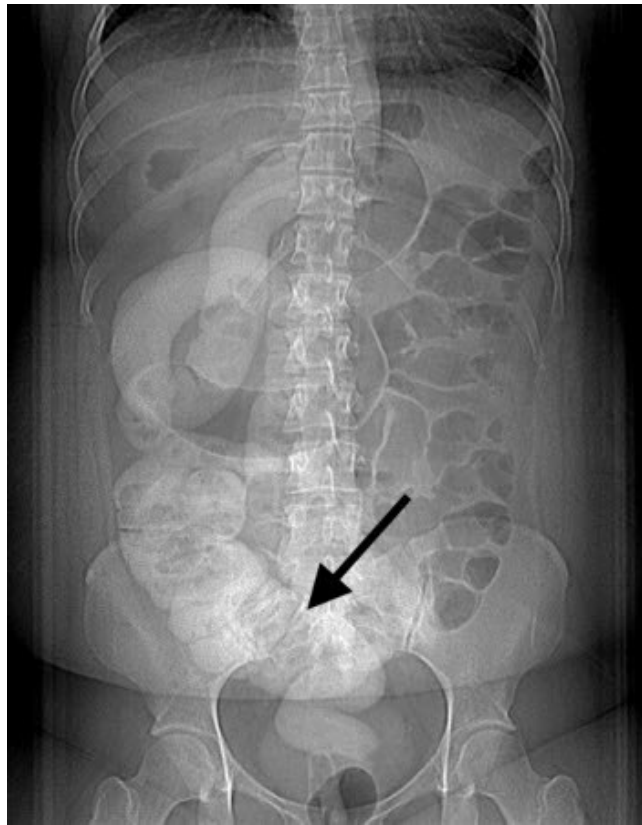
Computed Tomography: A 23 year-old female patient with situs ambiguous abnormality is shown on contrast enhanced CT topogram. The sigmoid colon is distinguished in the right lower quadrant by the arrow. The odd position of the colon is due to situs ambiguous.
